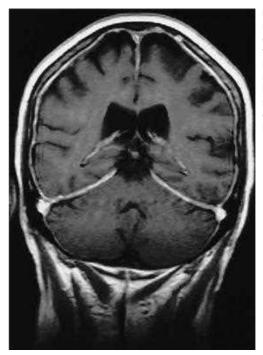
Magnetic resonance image (with gadolinium) of a patient with bilateral sixth cranial nerve palsy. The palsy resulted from intracranial hypotension after lumbar spine surgery. Note the diffuse enhancement of the meninges.
